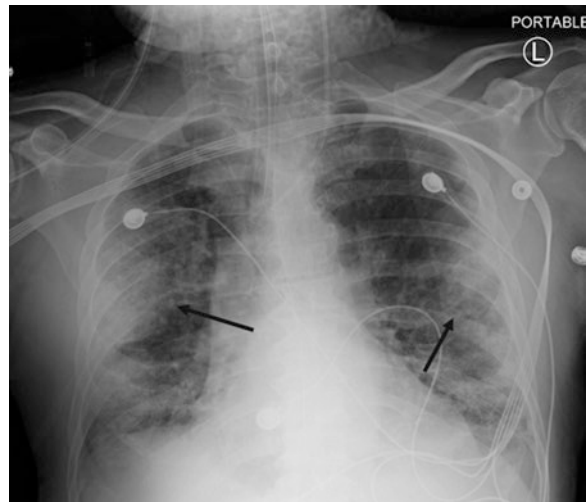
Chest X-ray from COVID-19 pneumonia. There are several areas of peripheral consolidations in both lungs (arrows)
